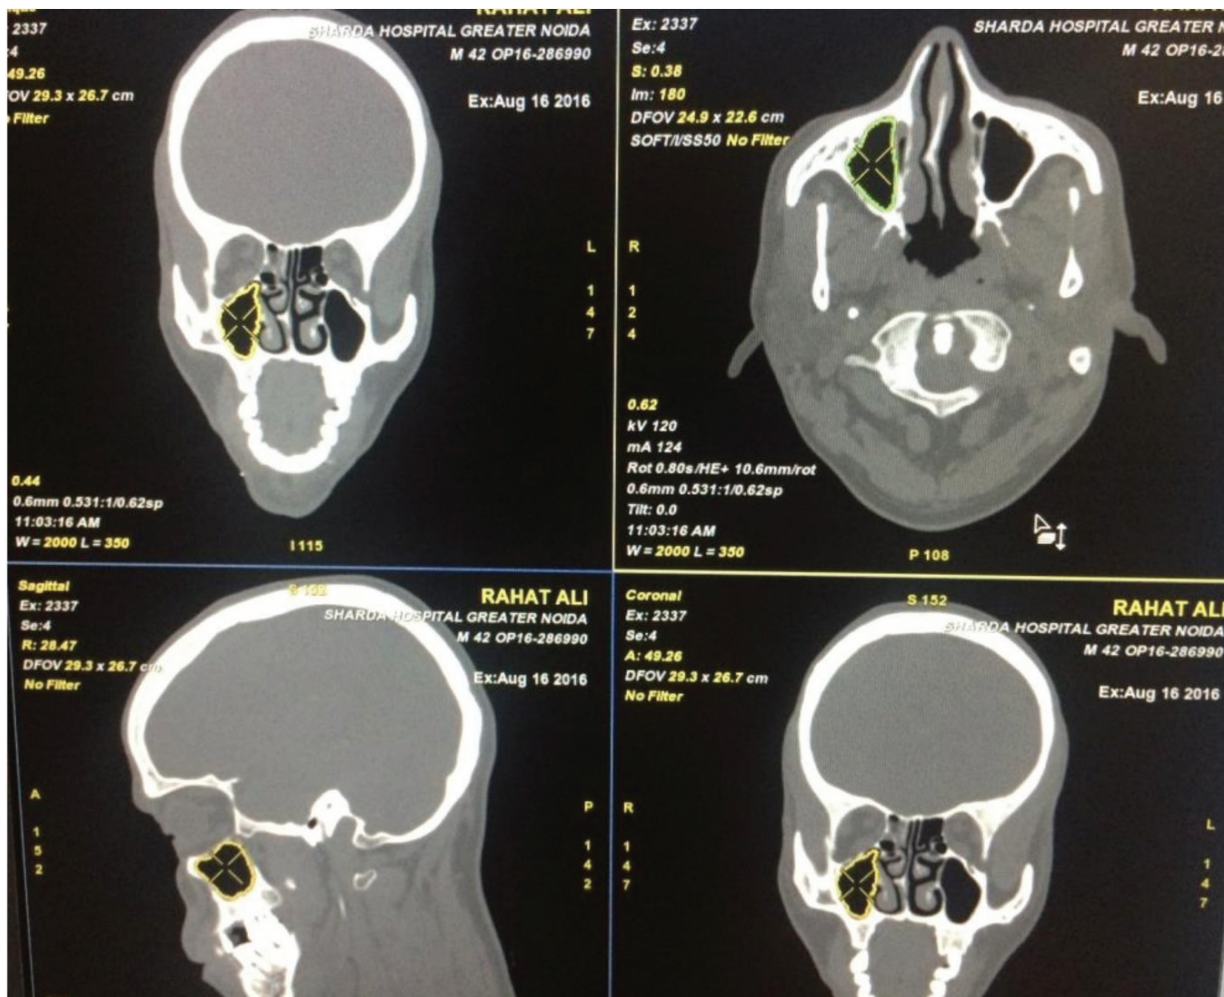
Maxillary sinus volume using Auto contour software on CT
